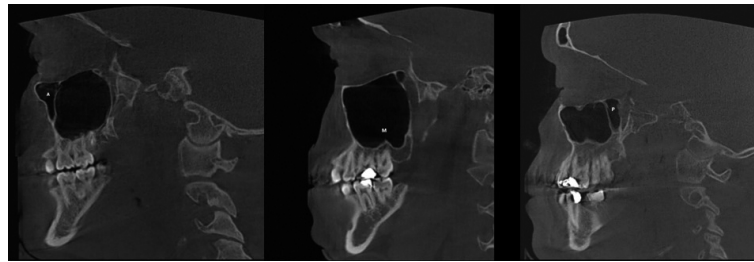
Locations of septa visualized on CBCT image in sagittal plane. A. Anterior; B. Middle; and C. Posterior.
